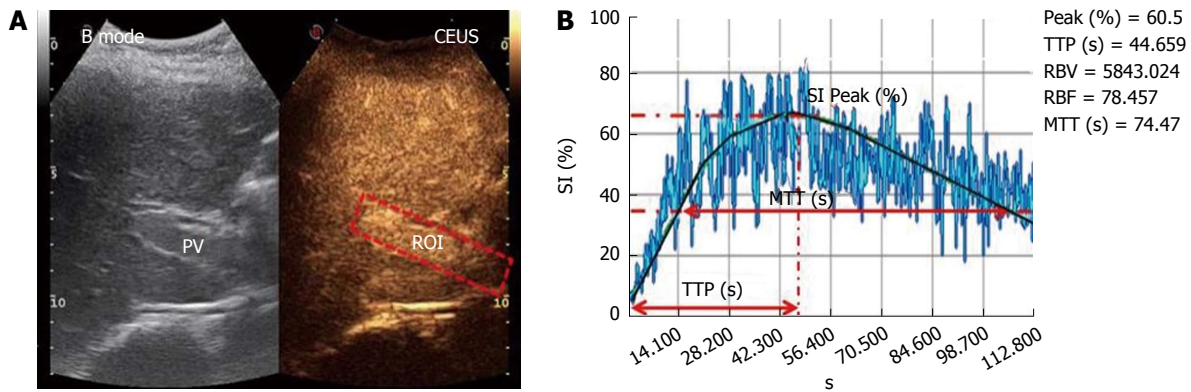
Example of region of interest selection in the portal vein and Qontrast®-assisted contrast-enhanced ultrasound analysis of portal vein parameters in healthy control. A: Region of interest (ROI) drawn in a region of the portal vein (PV) in a selected set of higher signal intensity frames 1 min and 10 s after SonoVue® injection; B: A gamma variate (bolus)-corrected parametric curve for the translational movement caused by breathing activity. SI (%): Signal intensity; PEAK (%): Maximum signal intensity reached during SonoVue® bolus injection; TTP (s): Time to peak; RBV (cm³): Regional blood volume; RBF (cm³/s): Regional blood flow; MTT (s): Mean transit time.
